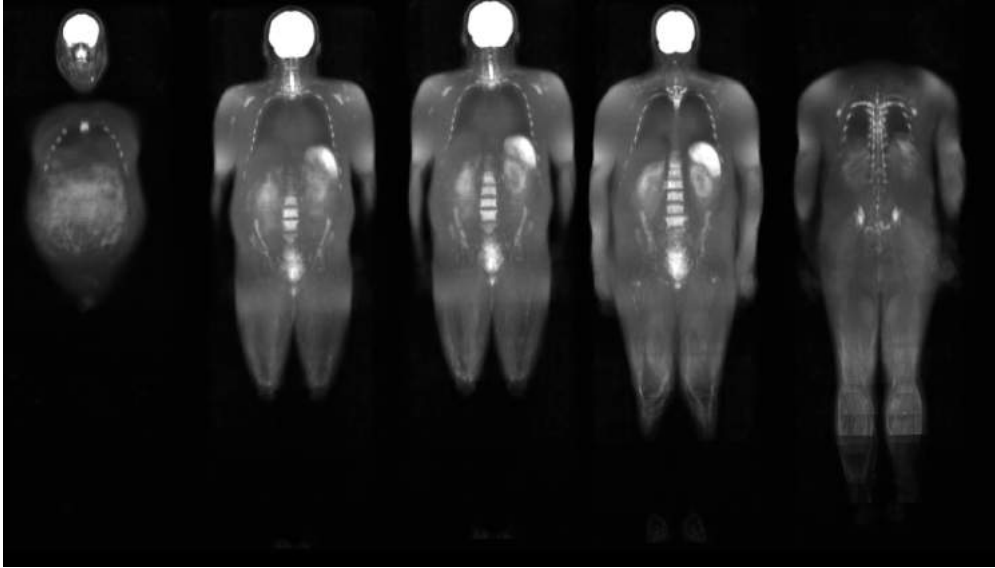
Male template image, built with nine DWI images and using the previously built template image as the fixed image. These five representative coronal slices do not show differences in the brain, spleen and bladder, when compared to the first male template. The kidneys, hip bones and vertebrae are converging to specific areas, achieving better alignments.
